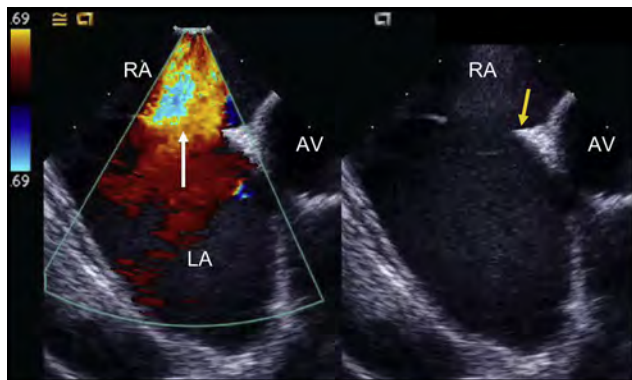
Intracardiac echocardiogram of an ostium secundum ASD with left to right flow with and without color Doppler mapping. The *white arrow* indicates the direction of ASD flow; *yellow arrow*, the aortic rim. AV, aortic valve.
